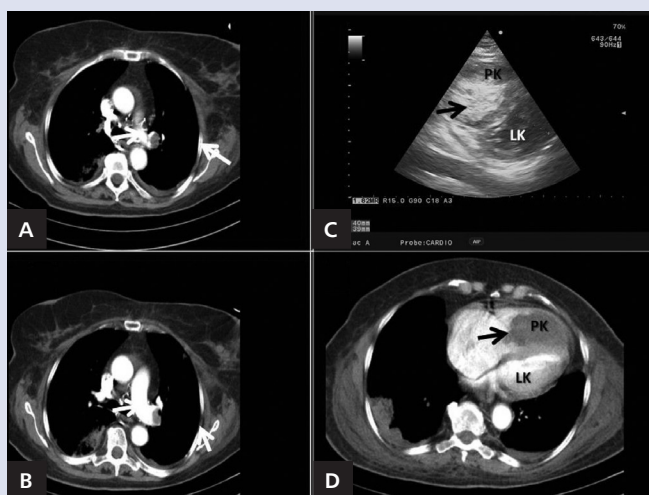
A, B. Angiography computed tomography — bilateral pulmonary embolism (white arrow); C. Echocardiography — parasternal, short axis view — giant thrombus filling whole right ventricle (PK) cavity (black arrow); D. Angiography computed tomography — enlarged right ventricle (PK) with giant thrombus filling almost the whole right ventricle cavity (black arrow); LK — left ventricle
